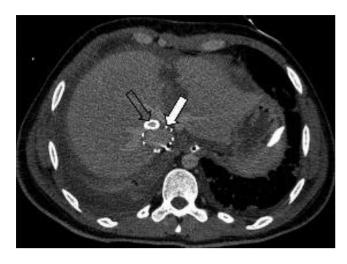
Post-procedure abdominal CT. The white arrow is pointing at the RHVC SG, and the transparent arrow is pointing at Viabahn CS. Both stents are working properly.
